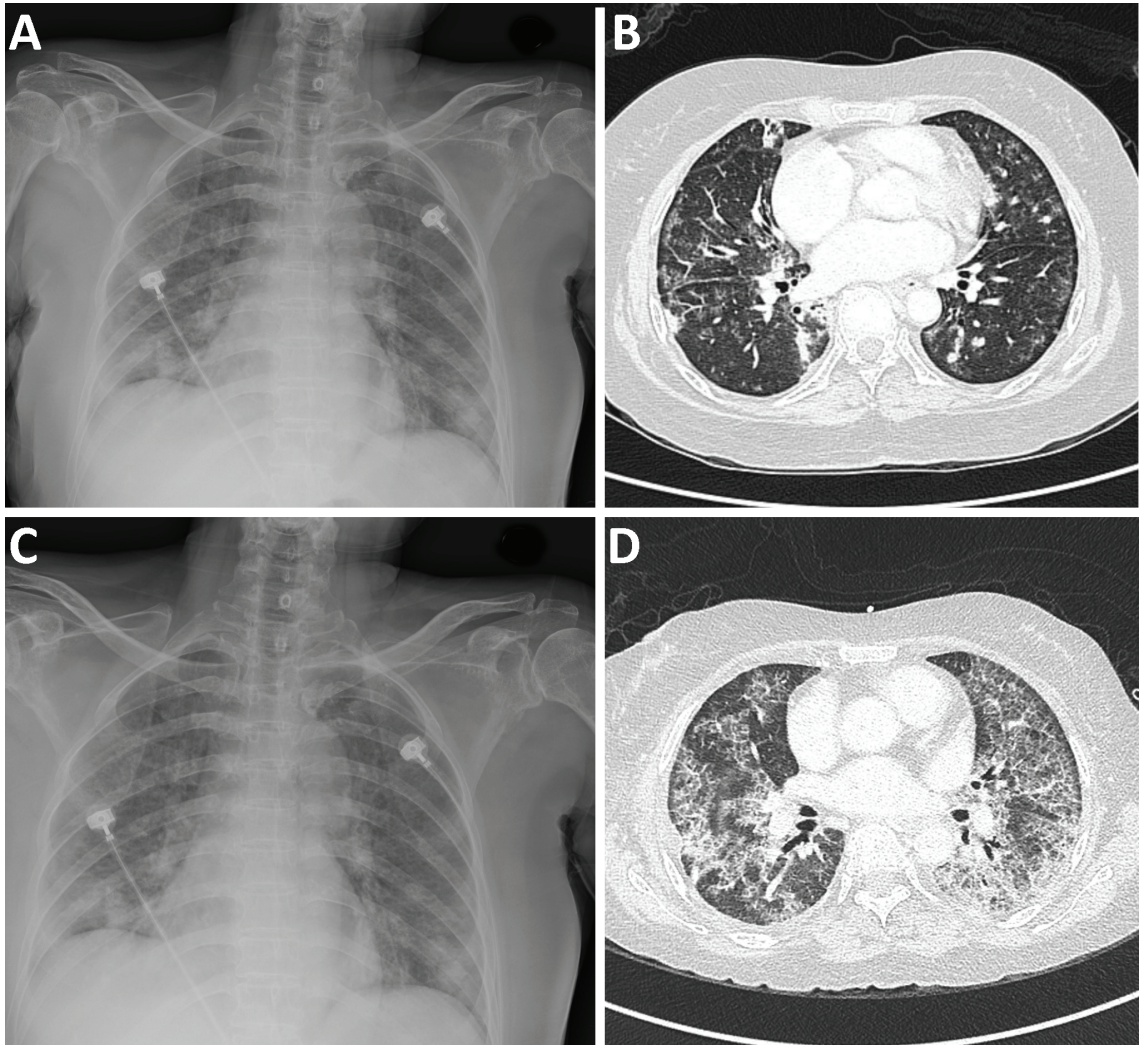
Radiographic appearance of the patient in March 2014 and October 2014. The chest radiograph (A) and high-resolution computed tomography (CT) of the chest (B) disclosed a non-specific inflammatory process in both lungs. The follow-up chest radiograph 7 months later (C) showed the "bat wings" distribution and thin lucent bands which sharply outlined the diaphragm and heart. There was no evidence of cardiomegaly, lymphadenopathy, or effusion. The follow-up CT of the chest (D) showed a typical "crazy-paving" pattern characterized by ground-glass opacity with superimposed interlobular and intralobular reticular septal thickening.
